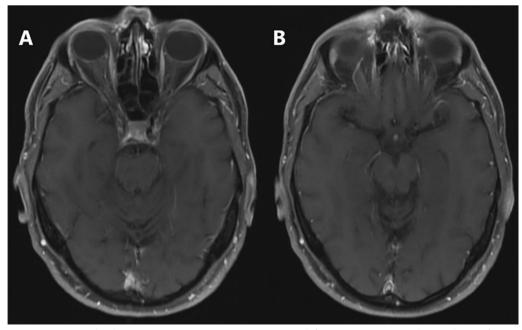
Axial post-contrast T1-weighted magnetic resonance imaging sequences with fat suppression. A Complete resolution of prior contrast enhancement in the posterior pons. B Absence of residual enhancement in the midbrain. Compare with Fig. 6
